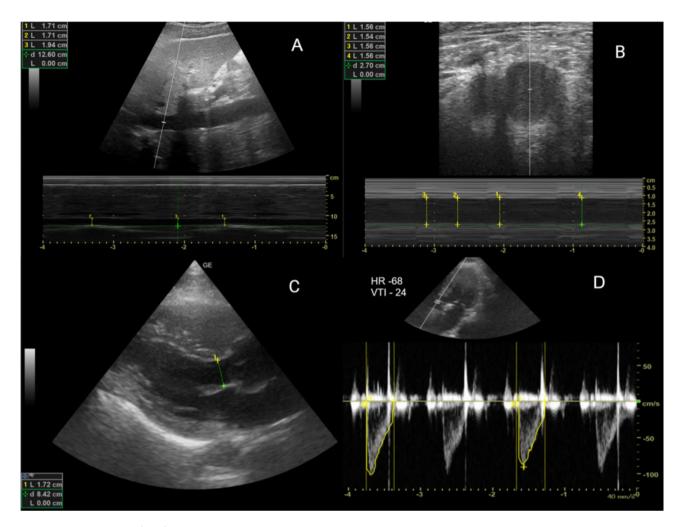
Ultrasound images of IVC, femoral vein & LVOT-VTI
